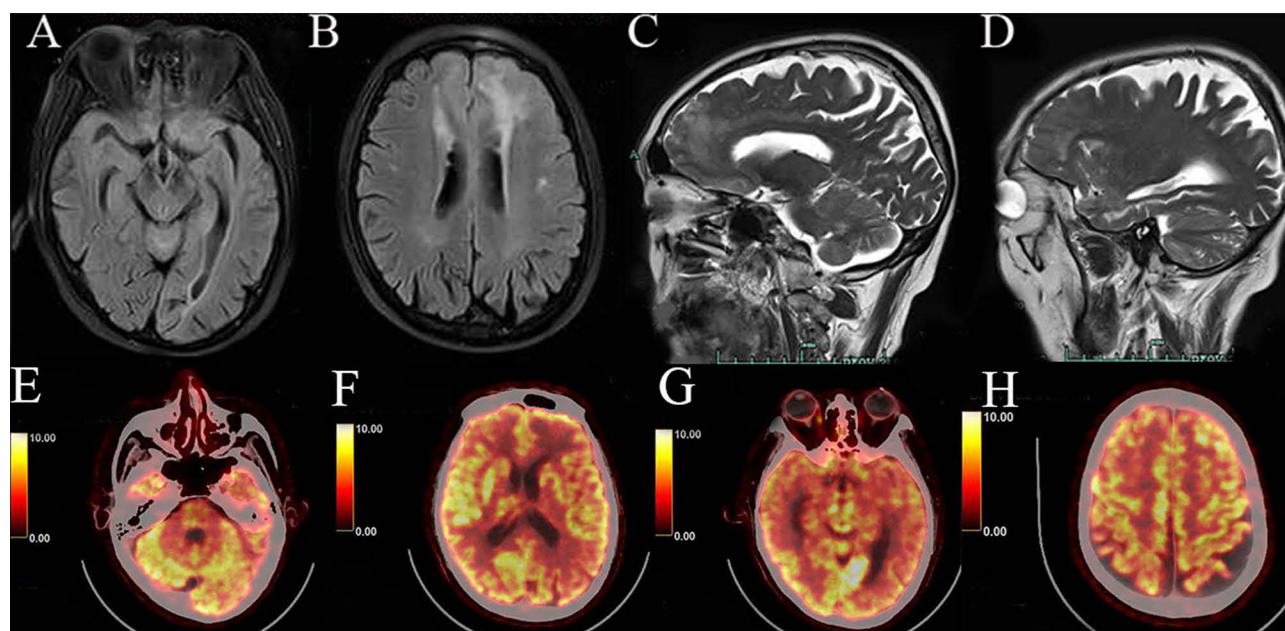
Brain MRI and PET-CT findings. (A) Initial axial T2-weighted FLAIR MRI (3T Siemens Magnetom Skyra; TR/TE/TI = 9000/90/2500 ms) at the level of the cerebellar vermis at symptom onset, showing non-enhancing punctate hyperintensities. Scale bar: 1 cm. (B) Initial axial T2-weighted FLAIR MRI (same parameters as (A)) at an adjacent level of the cerebellar vermis, demonstrating patchy hyperintensities. Scale bar: 1 cm. (C) Initial axial T2-weighted FLAIR MRI (same parameters as (A)) at the level of the frontal lobes, revealing punctate hyperintensities in the bilateral frontal subcortical white matter. Scale bar: 1 cm. (D) Initial axial T2-weighted FLAIR MRI (same parameters as (A)) at a slightly higher level of the frontal lobes, showing confluent patchy hyperintensities. Scale bar: 1 cm. (E) Fused axial [^{18}F]FDG PET-CT image (GE Discovery Max+; 45–60 min post-injection; SUV scale 0–5) corresponding to the cerebellar level in (A) and (E), demonstrating marked hypometabolism in the vermis. Scale bar: 1 cm. (F) Fused axial [^{18}F]FDG PET-CT image corresponding to the cerebellar level in (B) and (F), confirming extensive cerebellar hypometabolism. Scale bar: 1 cm. (G) Fused axial [^{18}F]FDG PET-CT image corresponding to the frontal lobe level in (C) and (G), showing significant hypometabolism in the bilateral frontal cortices. Scale bar: 1 cm. (H) Fused axial [^{18}F]FDG PET-CT image corresponding to the frontal lobe level in (D) and (H), revealing widespread frontal cortical hypometabolism. Scale bar: 1 cm.
